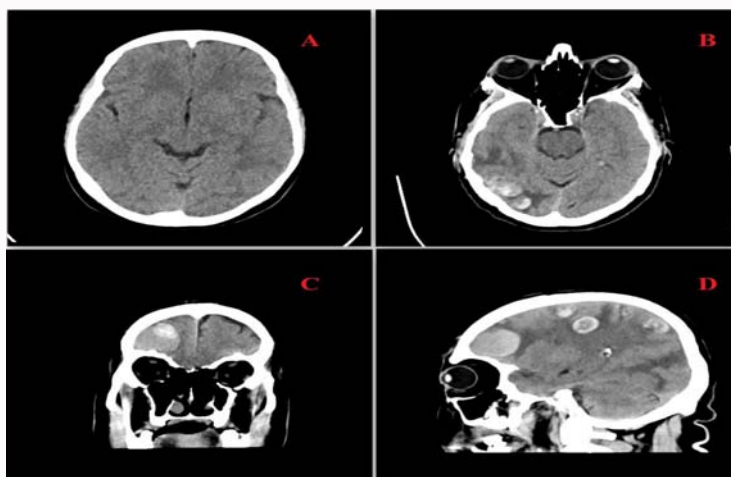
(A) Shows normal CT scan of brain, (B), (C) and (D) show possible brain metastases.
